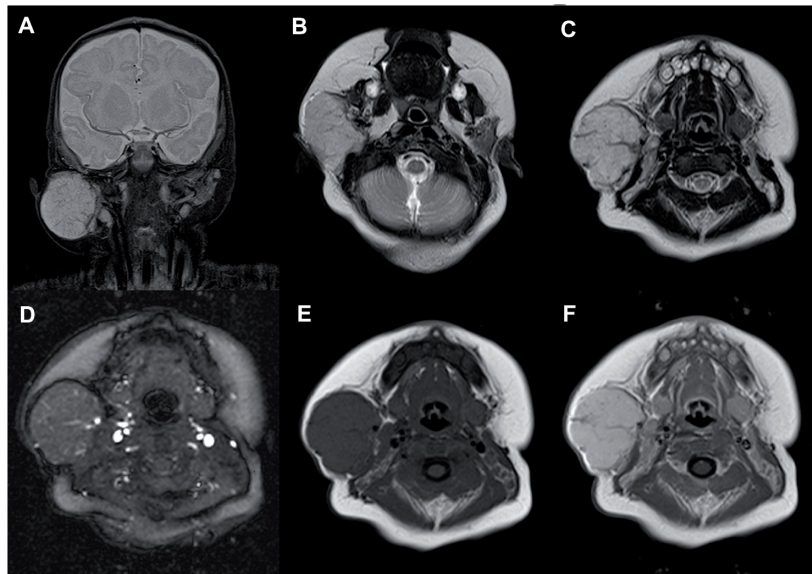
Two-month-old female with a proliferating right parotid hemangioma (Case 6). Coronal STIR T2-weighted (A) image shows a round, hyperintense mass to the right side of the neck. Transverse T2-weighted (B) image shows the mass is located in the right parotid gland. Transverse T2-weighted (C) and MR angiogram (D) images show a high velocity vessel producing a linear flow void within the medial aspect of the mass. T1-weighted images pre- (E) and post-gadobutrol administration (F) show marked homogeneous enhancement of the tumor.
